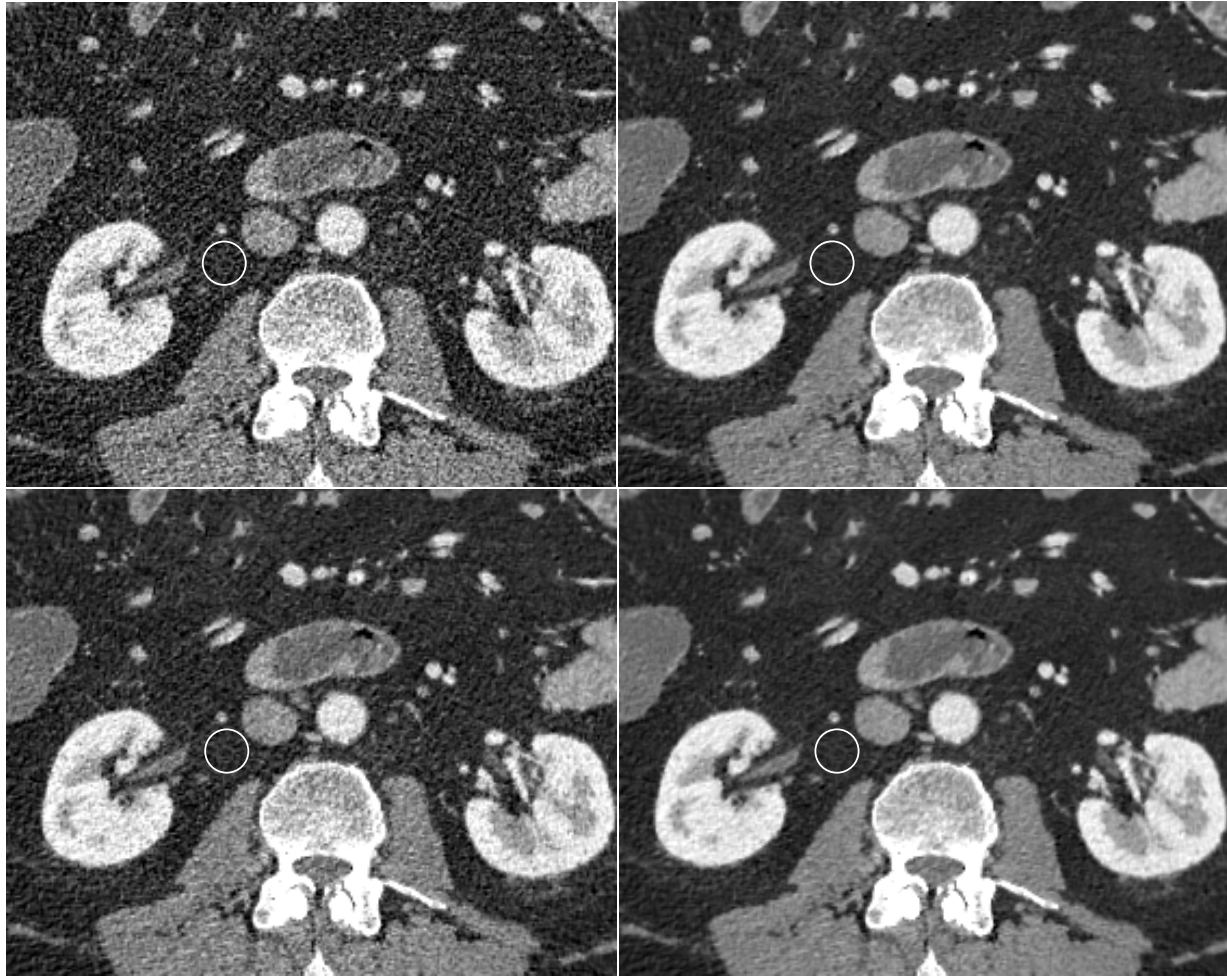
A different section of the same slice of the original half-dose abdominal CT scan from fig. 4 (top left), denoised with the noise map technique (top right), and denoised with standard NLM with low strength (bottom left) and high strength (bottom right). The noise map and NLM at high strength give effective denoising, but NLM with low strength gives less effective denoising. The standard deviations within the ROI are 48.3, 16.8, 29.4, and 16.2 HU.
